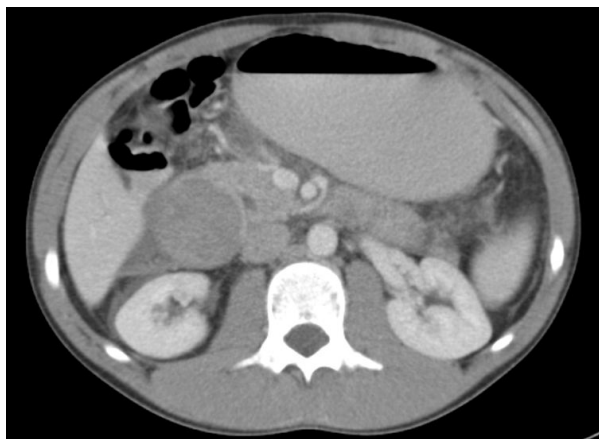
CT scan of the abdomen showing a rounded heterogeneous mass compressing the second part of duodenum. The bile duct is dilated and the stomach is distended.
